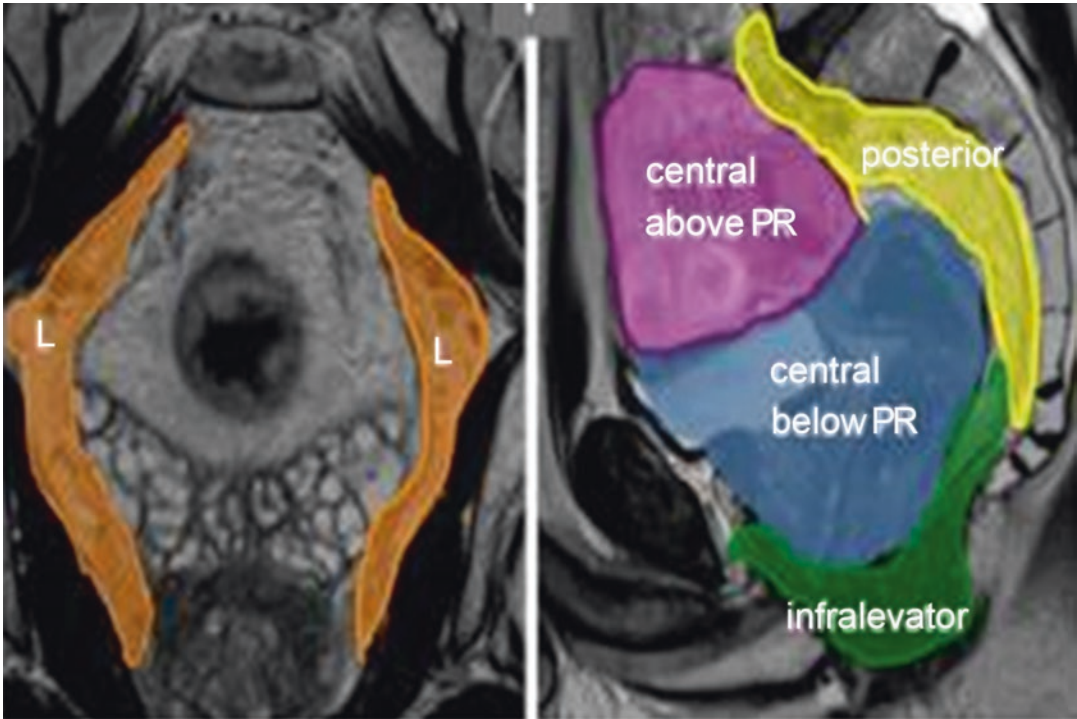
Compartmental pelvic staging for ‘Beyond TME’ surgery using high resolution MRI. Six distinct anatomical compartments are shown: Lateral (L); central above peritoneal reflection (PR); central below peritoneal
